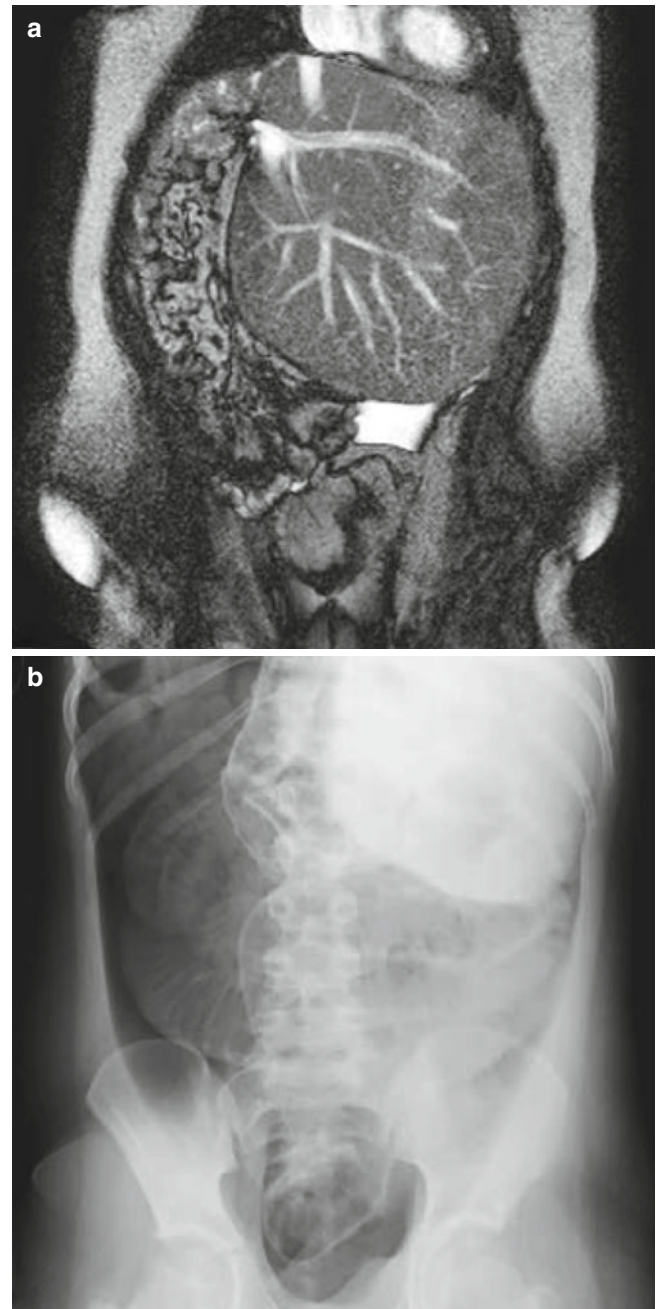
(a) This is a scan of a child with a familial rightsided hepatoblastoma that has been successfully resected and following treatment was cured. Genetic studies on the family revealed he had the APC gene mutation. On follow-up 3 years later he developed rectal bleeding. This scan shows compensatory growth of the residual normal left lobe of liver. (b) This x-ray demonstrates a complication of a pneumoperitoneum after an attempted biopsy of polyps in the colon. Multiple polyps were encountered. The patient had a total colectomy, and is well
